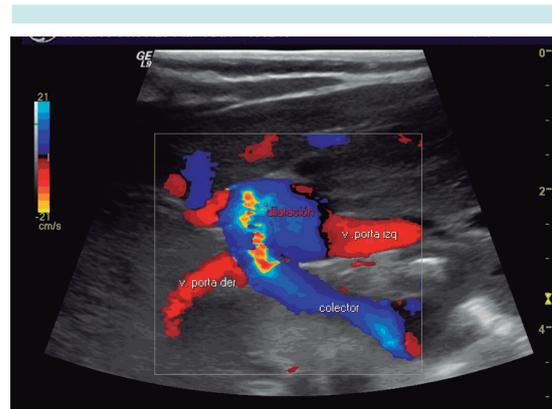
Abdominal Doppler color ultrasound showed the presence of an infracardiac collector draining to the portal vein.
